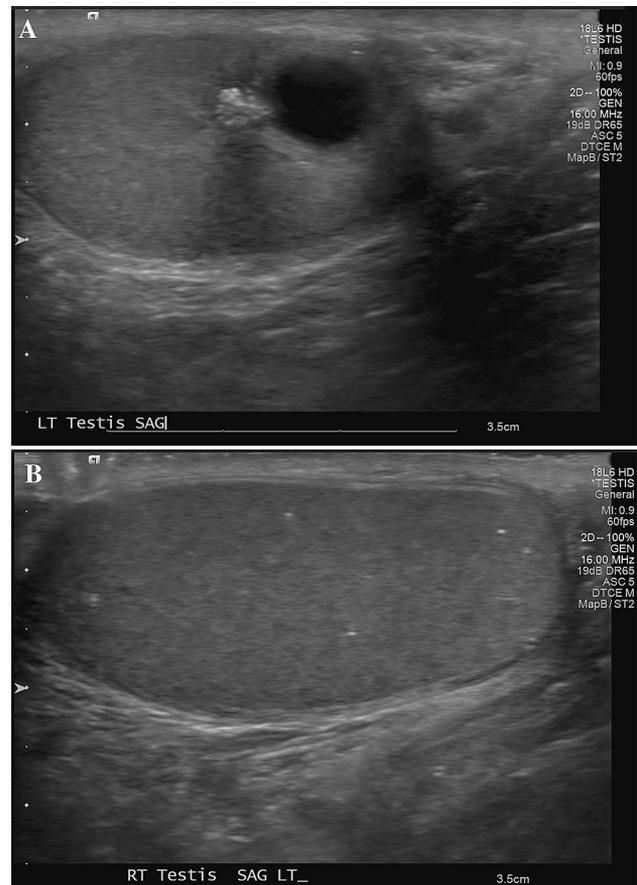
A Ultrasound of the left testicle in the same patient revealing an echogenic scar that includes an area with posterior acoustic shadowing, consistent with calcification adjacent to a rounded cyst. B Ultrasound of the larger right testicle demonstrates a background of microlithiasis.
